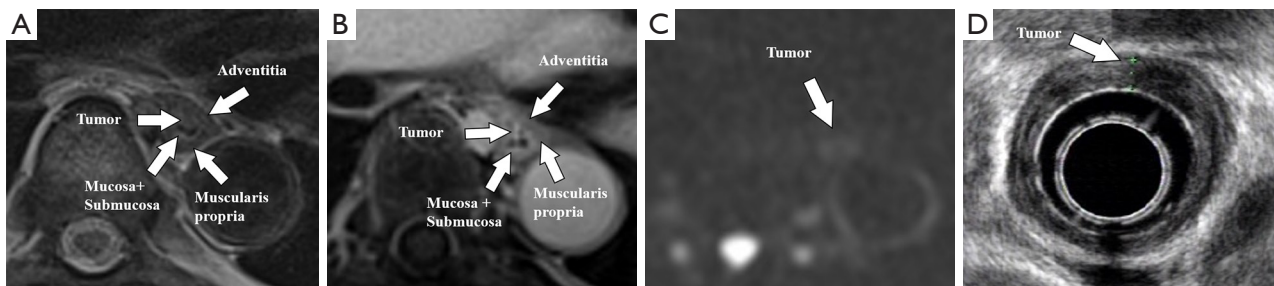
A 49-year-old male patient with T1 esophageal cancer: (A) T2WI BLADE, (B) enhanced T1WI StarVIBE, (C) DWI ($b = 800$), and (D) EUS. The tumor is located in the mucosa and submucosa and protrudes into the lumen without muscularis propria invasion. T2WI, T2-weighted imaging; T1WI, T1-weighted imaging; StarVIBE, stack-of-stars volume interpolated breath-hold examination; DWI, diffusion-weighted imaging; EUS, endoscopic ultrasound.
